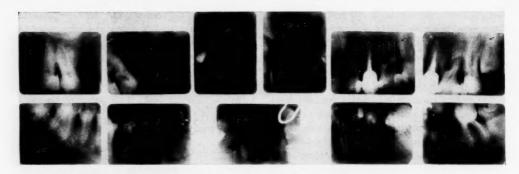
(Case 4) Above: Roentgenograms of the teeth before treatment. Left: Dentition after treatment
